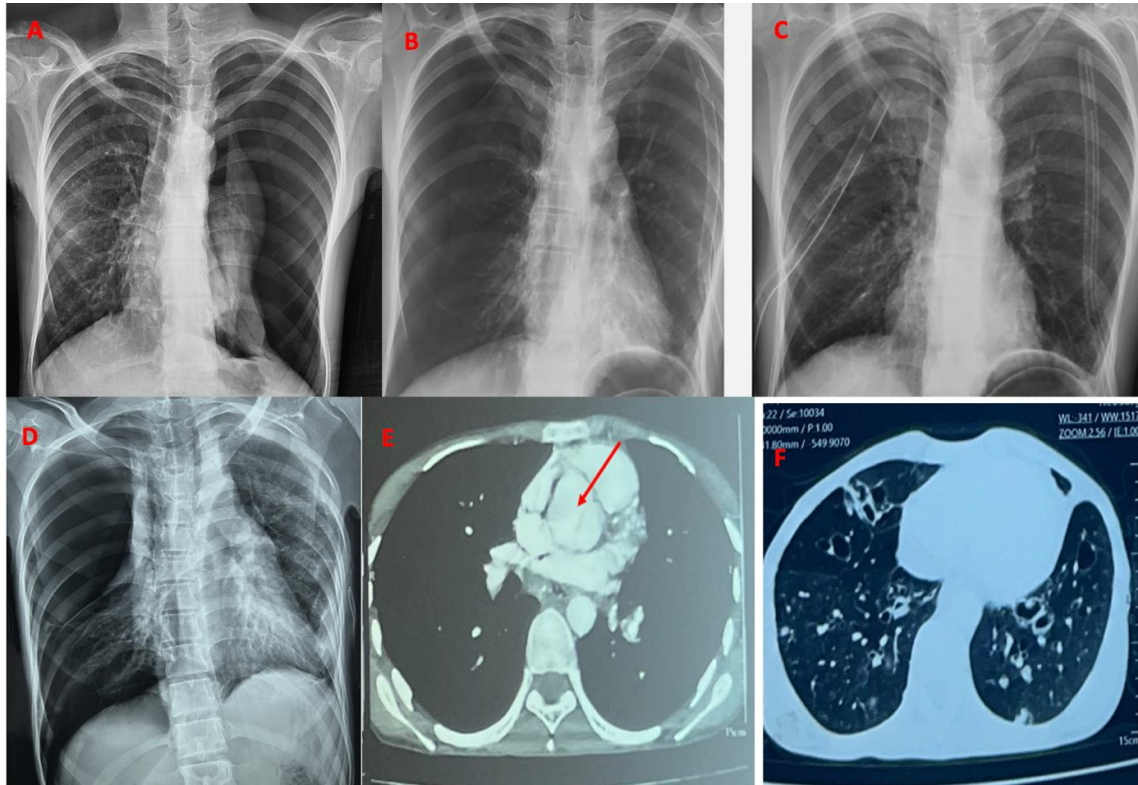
Thoracic imaging. A: Chest x-ray showing a left pneumothorax B,C: Chest x-rays showing a drained bilateral pneumothorax D: Chest x-ray showing recurrence of the right pneumothorax E: Chest CT angiogram showing dilation of the ascending aorta F: Parenchymal CT section showing dilations of bronchi, mosaic appearance and micronodular infiltrates of fowlers
